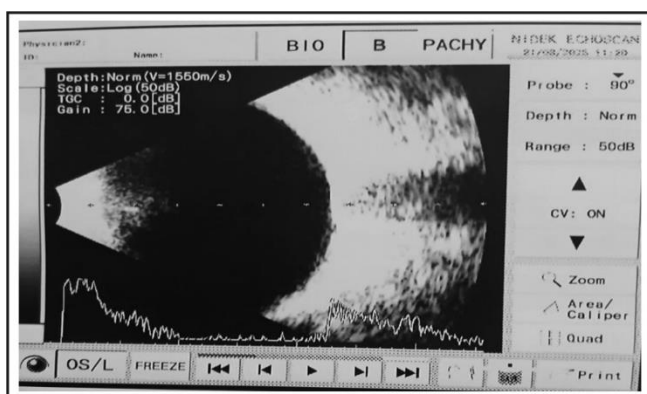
B-scan ultrasonography showing a clear vitreous and flat retina in the left eye.
